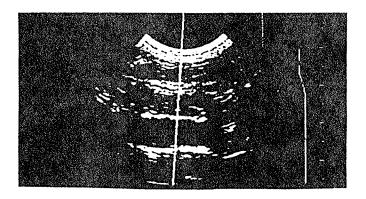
Long-axis ultrasound image of a human carotid artery
